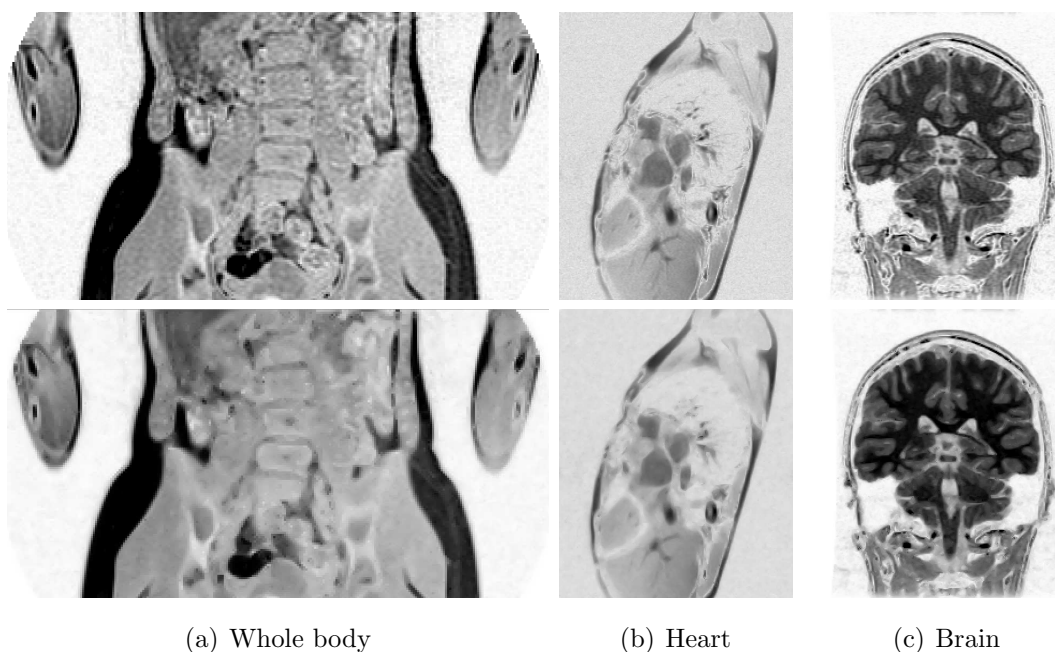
Adaptive smoothing applied to three types of MRI data. The filter is easily tuned to the particular characteristics of the data being smoothed, taking into account the levels of noise present and the boundary strengths observed at the interfaces between important regions in the data.
